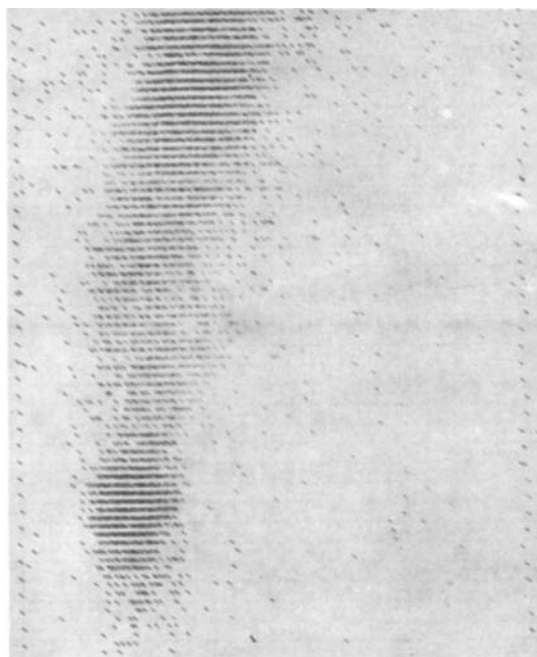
Bladder cancer, stage T4N1M1. Lymphoscintigram reveals tumour in the left half of the bladder and complete block of lymph drainage and the passage of isotope on the left side, beginning with femoral lymph nodes
